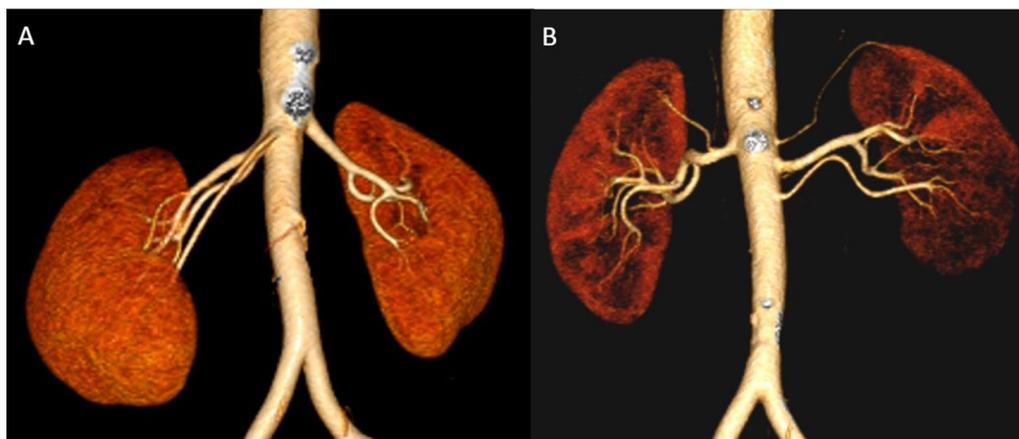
Contrast CT VRT images of DECT (A) and Turbo Flash (B) of the aorta and renal arteries shows comparable image quality between both
